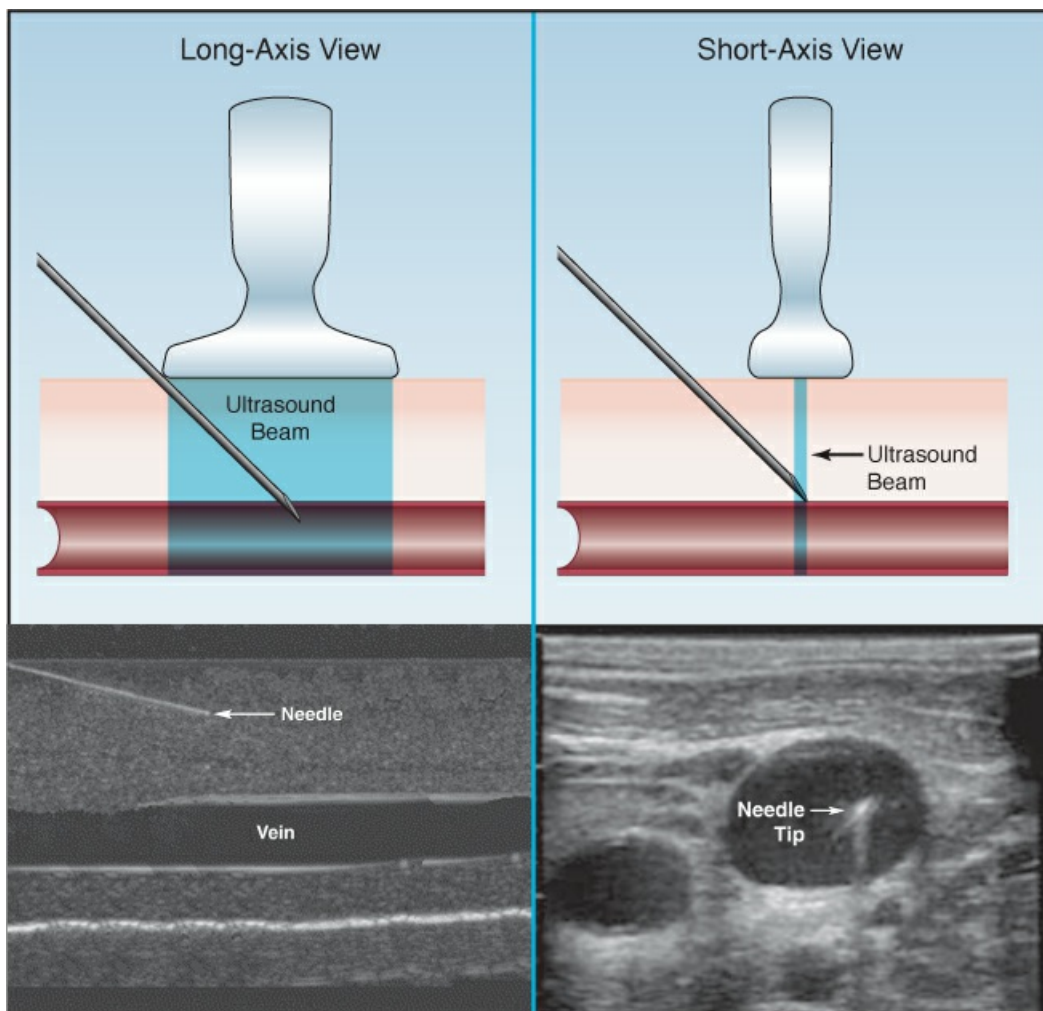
Orientation of the ultrasound beam in the long-axis and short-axis view, and how this influences the ability to visualize the probe needle. See text for further explanation.
